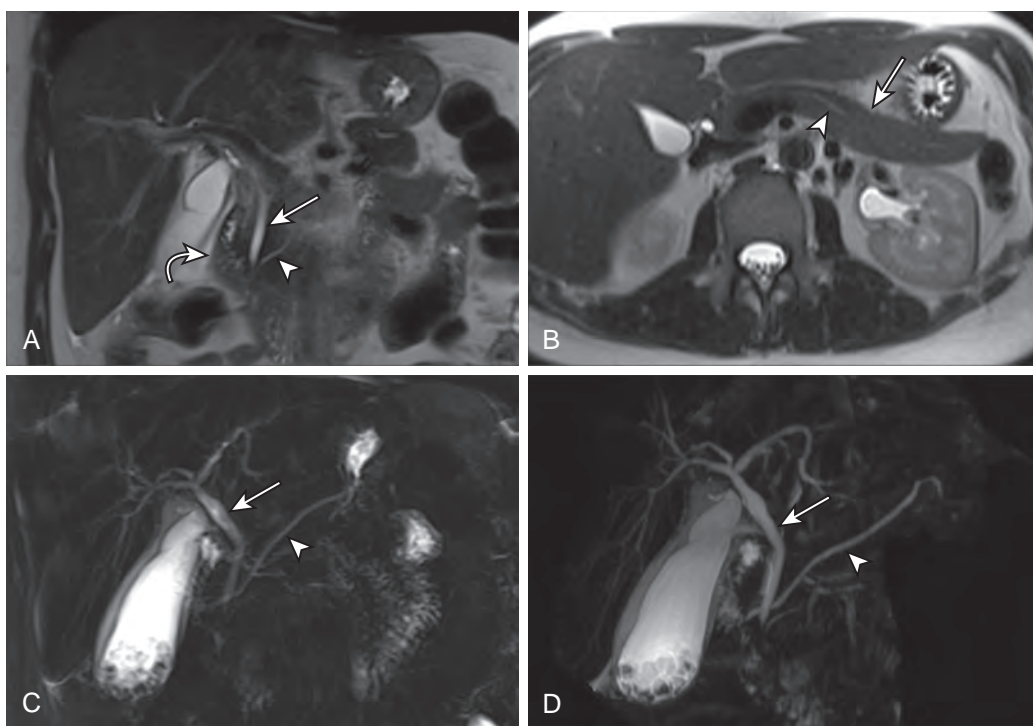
Normal MRCP. A. Coronal thin-section 3-mm T2-weighted half-Fourier acquisition single-shot turbo spin-echo (HASTE) image (1200/92/154) shows the common duct (arrow) and the pancreatic duct (arrowhead). Nondilated duodenum is also seen (curved arrow). B. Axial thin-section 3-mm T2-weighted HASTE image (1300/900/120) shows the normal appearance of the pancreatic body and tail (arrow). A nondilated pancreatic duct is partially visualized (arrowhead). C. Coronal thick-slab rapid acquisition and relaxation enhancement (RARE) image (3000/735/180) shows the common bile duct (arrow) and pancreatic duct (arrowhead). There is the suggestion of pancreatic divisum on this image. Filling defects in the gallbladder are compatible with gallstones. Gallbladder wall thickening is also present. D. Maximum intensity projection T2-weighted navigator sequence (3517/696/120) is able to locate the position of the diaphragm and thus correct for diaphragmatic motion to minimize respiratory motion and artifact. This maximum intensity projection image nicely displays the common bile duct (arrow) and pancreatic duct (arrowhead). Gallstones are again noted in the gallbladder lumen, and the presence of pancreatic divisum is confirmed on this image.
